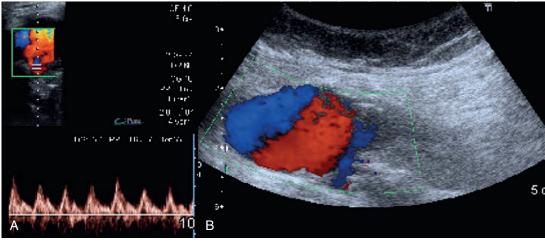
Sonography of popliteal fossa with systolic bruit (A) and longitudinal color Doppler ultrasound (B) show arterial blood. (From Tejero-Garcia S, Lirola Criado JF, Ast MP, et al: Popliteal pseudoaneurysm after unicompartmental knee replacement: a case report. Knee 21[2]:597-599, 2014.)
